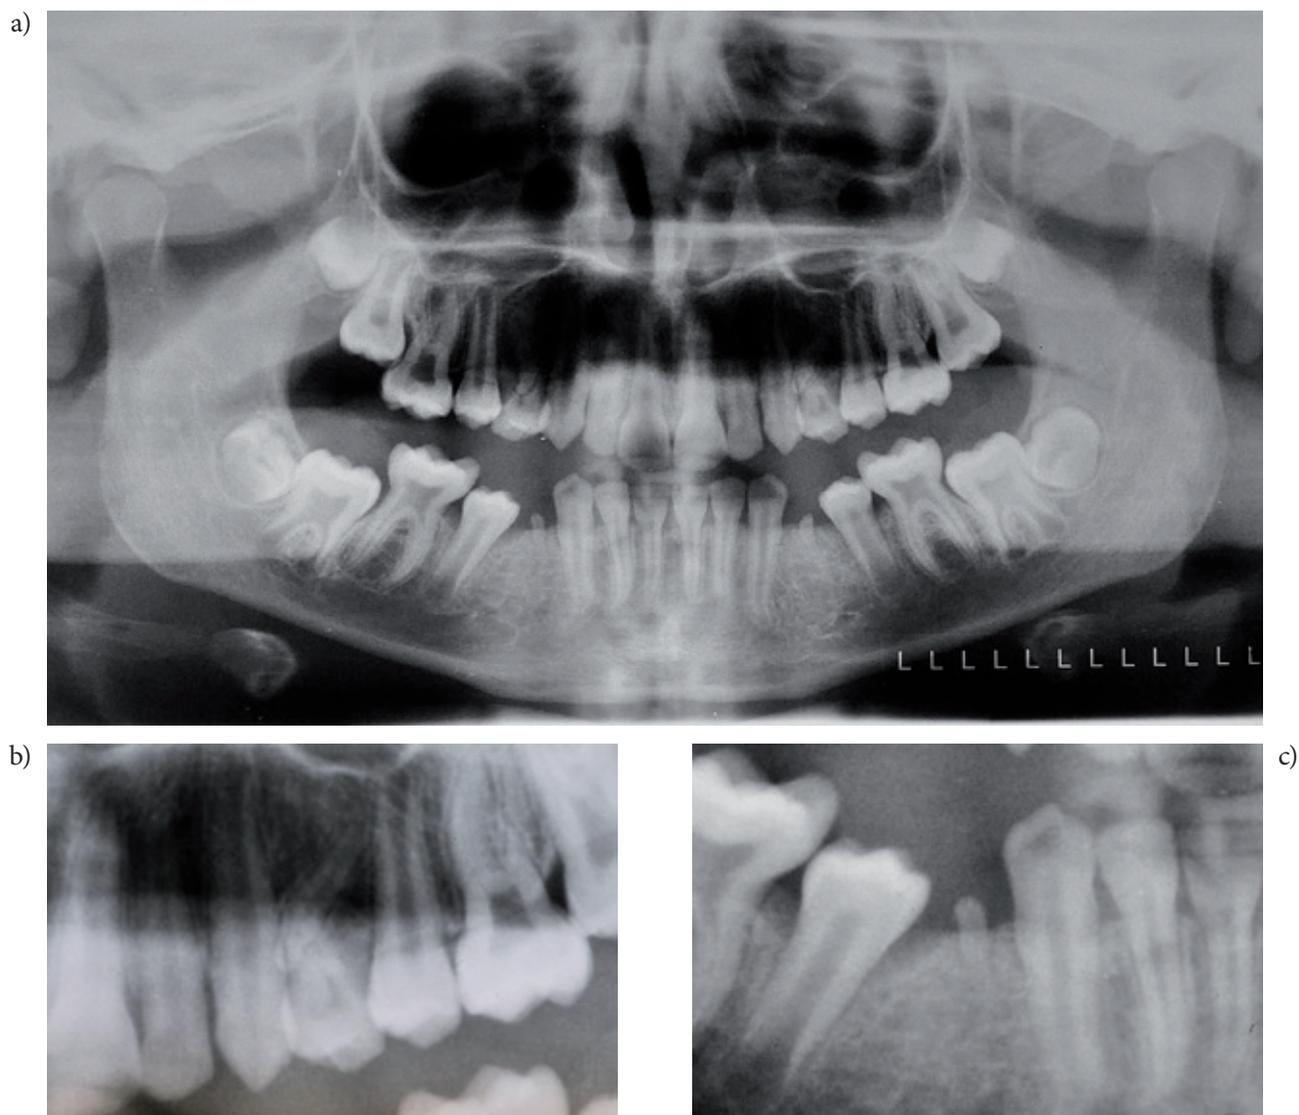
Panoramic radiograph of patient aged 11: a) whole dentition; b) magnification of region 64 (24); c) magnification of region 44
